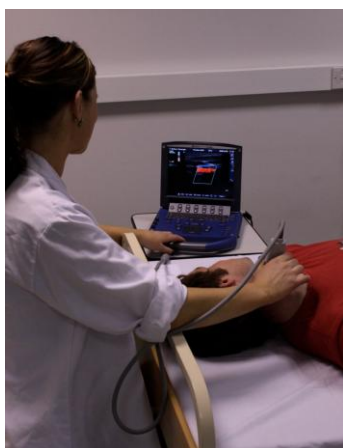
Carotid artery ultrasound reactivity
